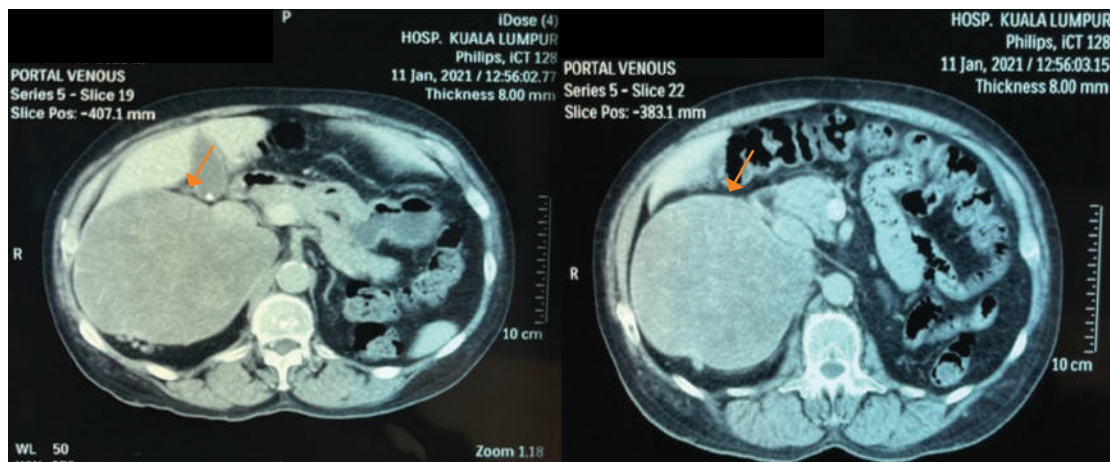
Coronal Section Contrast-Enhanced CT Adrenal images in portovenous phase showing a large heterogeneous enhancing right adrenal mass with no calcification or fat component within (arrow). The density of the mass on the plain study is 41 HU, in portovenous phase 53 HU, and delayed study 71 HU.
